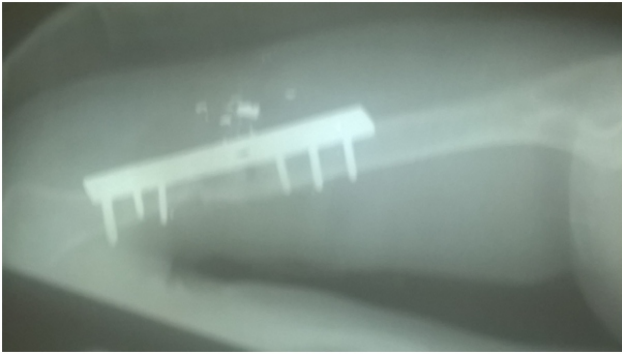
6 weeks post operative radiograph.
